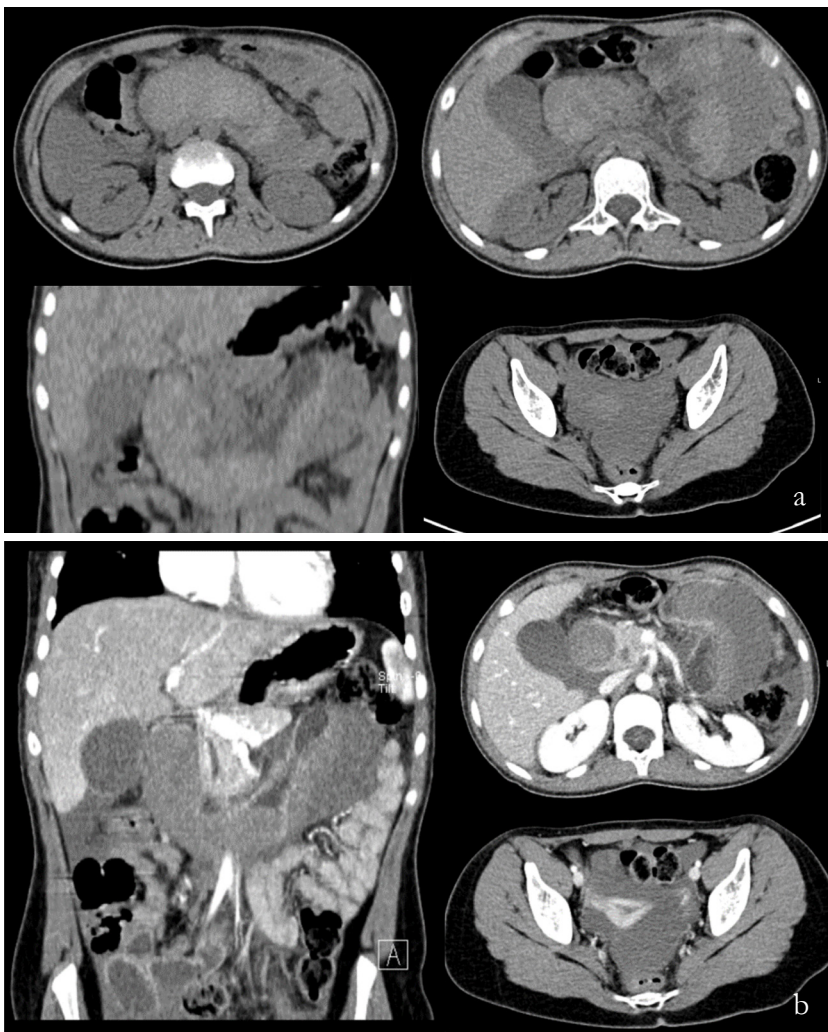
Computed tomography before (a) and after (b) intravenous contrast, with axial and coronal reconstructions reveals a heterogeneous collection, spontaneously hyperdense, without contrast enhancement, that follows the duodenum from the second to fourth portion, compatible with intramural duodenal hematoma. Absence of dilation of the bile ducts. The pancreas presents normal dimensions and homogenous enhancement. Moderate amount of fluid in the pelvic excavation.
